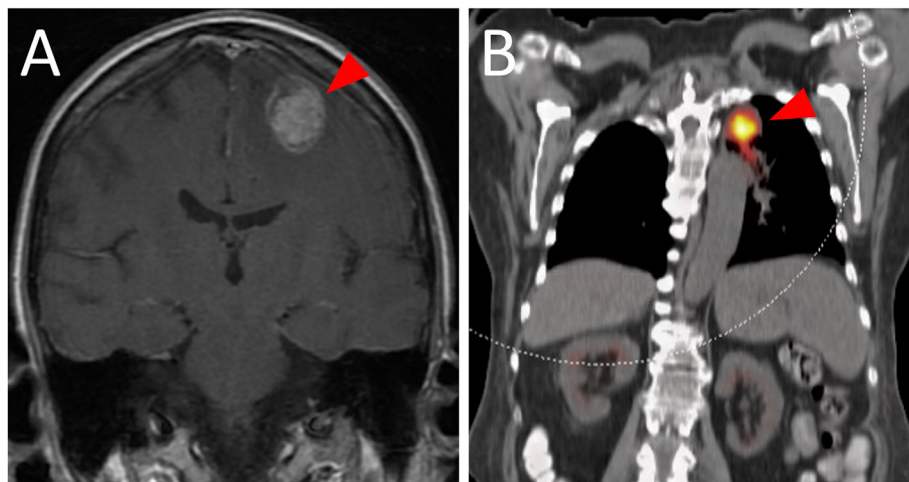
Magnetic Resonance and Positron Emission Tomography Imaging. MRI (Panel A) demonstrates a heterogeneously enhancing metastatic lesion within the left frontal lobe and associated vasogenic edema (arrowhead), consistent with metastasis. PET-CT (Panel B) demonstrates a hypermetabolic lobulated mass medial left upper lobe that extends contiguously into the left hilum compatible with metastasis.
